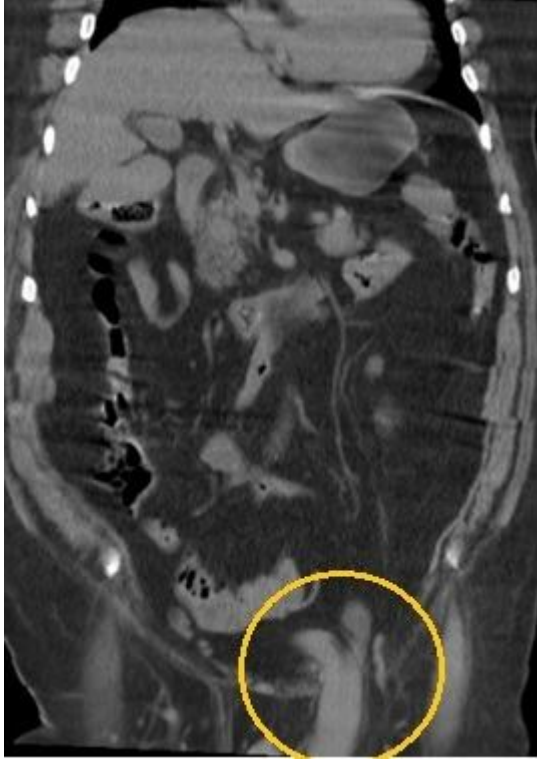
Non-contrast Abdominopelvic CT, with the presence of a left inguinal hernia, with evidence of protrusion of the urinary bladder and lower third of the ipsilateral ureter, located within the hernial sac
